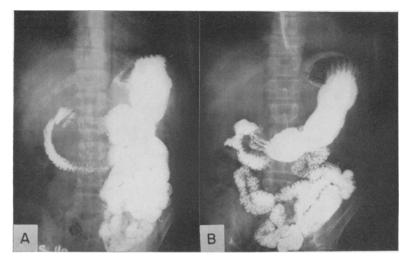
a) Preoperative upper gastro-intestinal x-ray demonstrates enlargement of the duodenal sweep and smooth flattening of inner border. b) Postoperative x-ray shows the duodenal sweep to be normal in contour and size.
